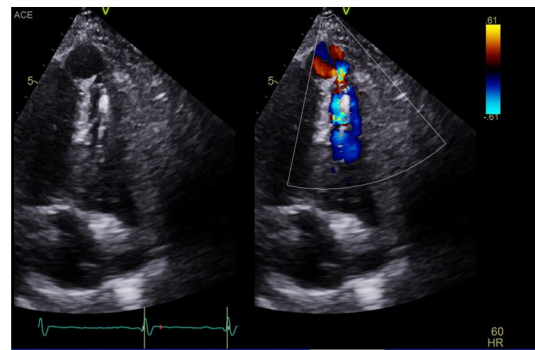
Transthoracic echocardiogram apical 4-chamber view revealed a left ventricular apical pseudoaneurysm (1.6 cm x 1.4 cm) with associated apical VSD (7 mm width).
